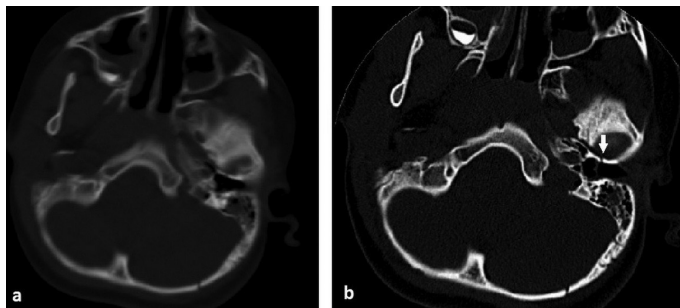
Axial non-contrast cranial (a) and temporal bone CT (b). Axial high-resolution multi-detector CT image of the temporal bone reveals a fracture on the anterior wall of the external auditory canal
